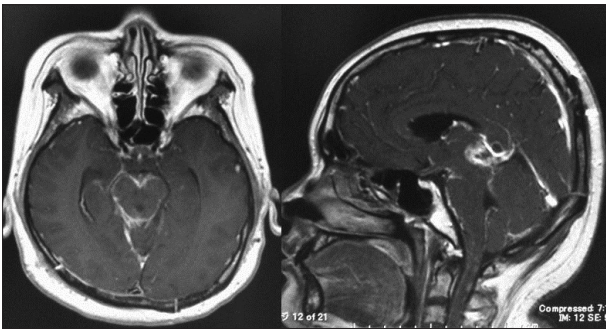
Postoperative enhanced magnetic resonance images revealing an enhancement surrounding the brainstem and the residual tumor in the pineal region after radiotherapy concomitant chemotherapy.
